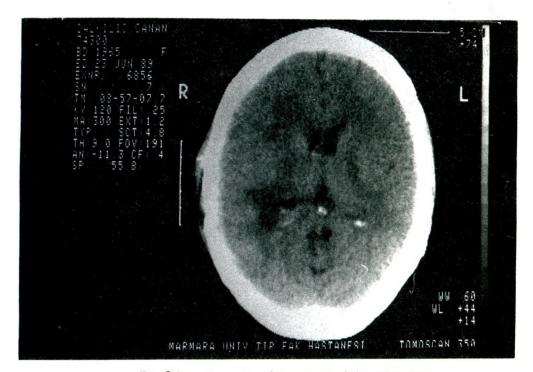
Postoperative CT scanner of the same case revealed a total resection.
